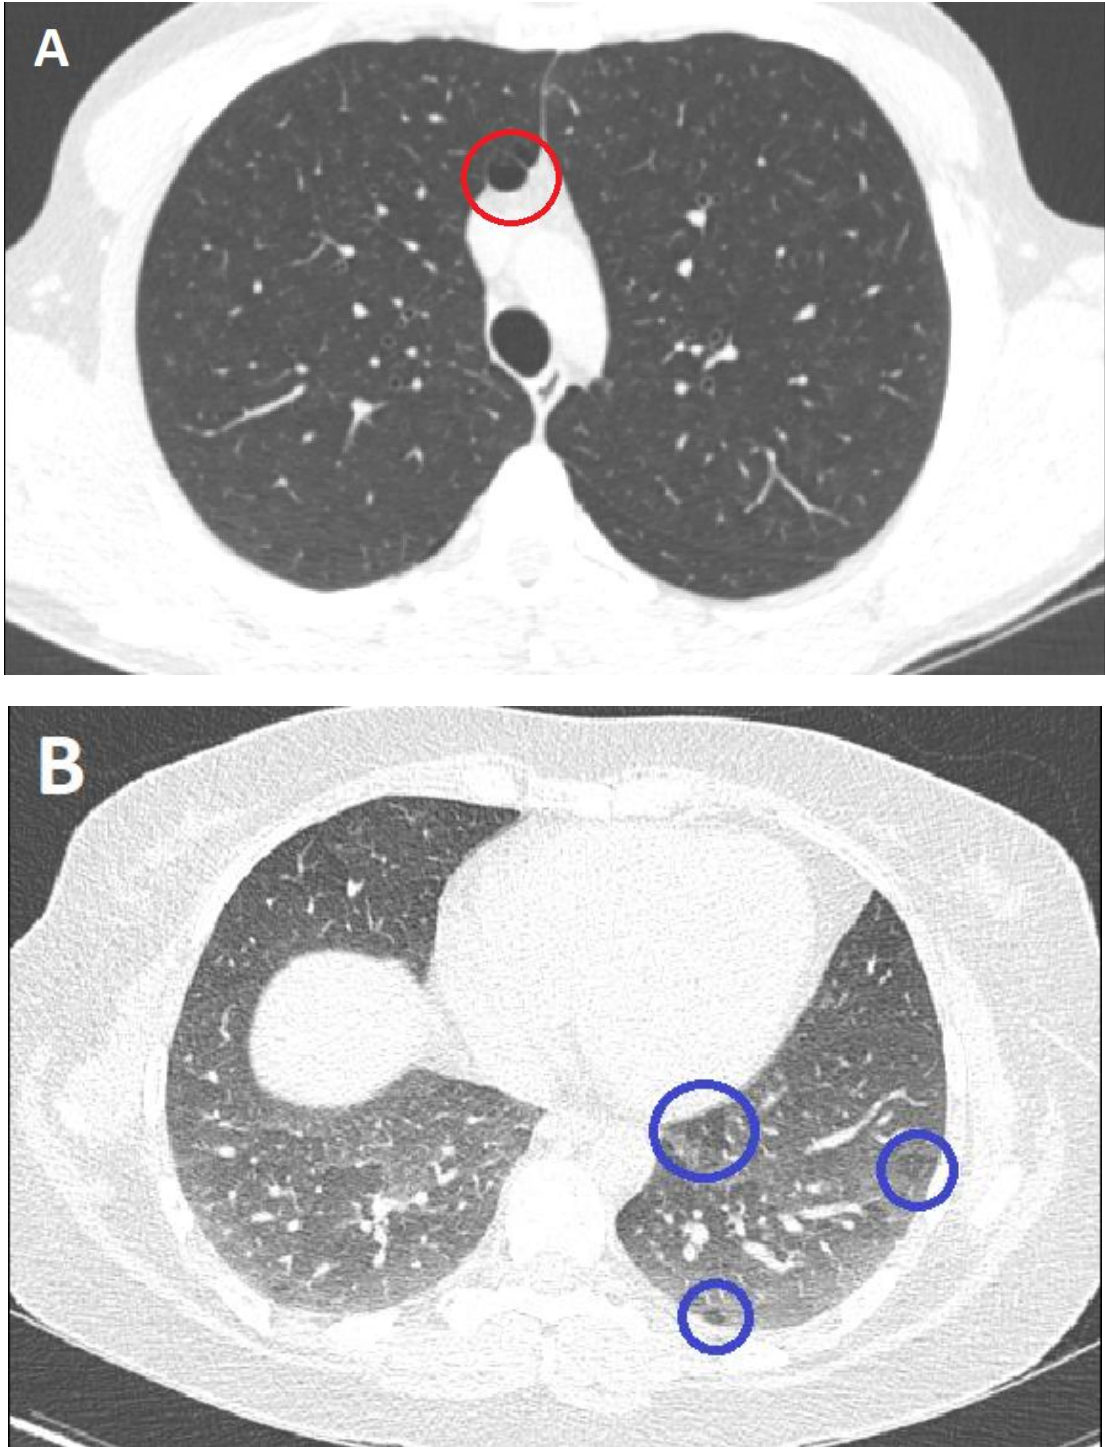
Example of CT chest images showing emphysema (A) and air trapping (B)
